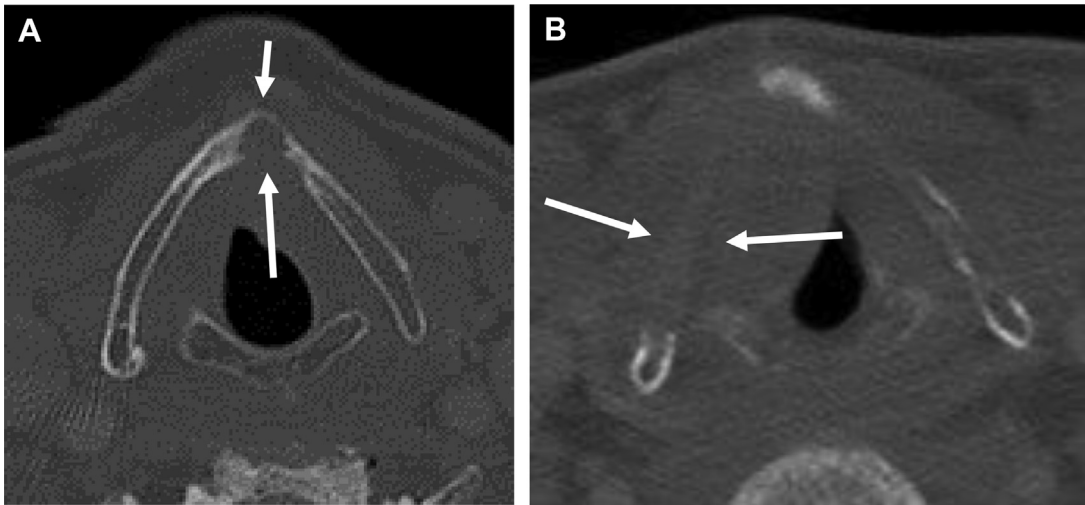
CT of laryngeal cartilage invasion. (A) Axial CT was obtained through the thyroid cartilage reconstructed in bone algorithms in a patient with an SCCA of the anterior commissure. Cancer has eroded the inner cortex (*long arrow*) but the outer cortex is preserved (*short arrow*) indicating the stage of the tumor is T3. (B) Axial CT was obtained through the thyroid cartilage reconstructed in bone algorithms in a patient with an SCCA of the right true vocal cord. Cancer has eroded both the inner cortex (*long arrow*) and outer cortex (*short arrow*), indicating the stage of the tumor is T4.
